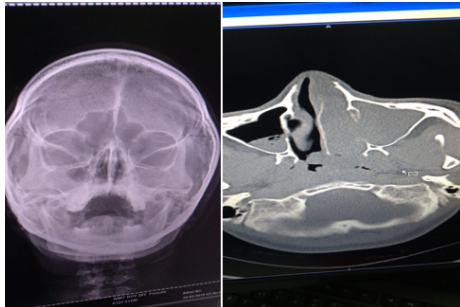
CT shows mucosal thickening but X-RAY could not detect it
